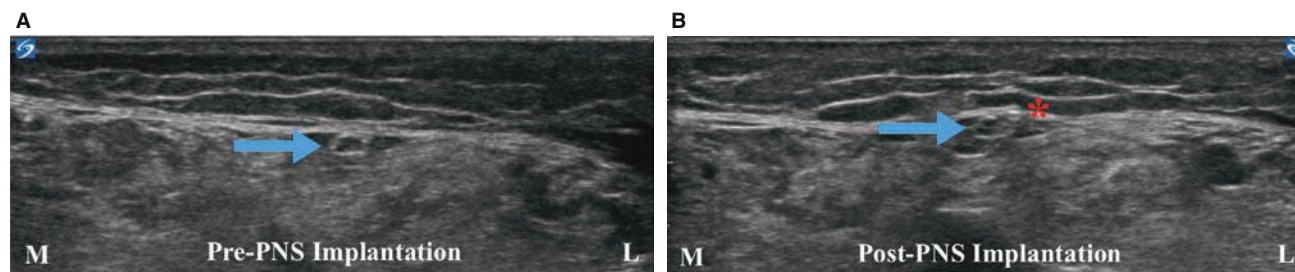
A, Intraoperative ultrasound imaging showcasing the trajectory of the superficial peroneal nerve between the anterior and lateral leg compartments (before stimulator implantation). Blue arrow points to the superficial peroneal nerve (fascicular bundle to the right of the arrow). L, lateral; M, medial; PNS, peripheral nerve stimulator. B, Intraoperative ultrasound imaging showcasing the percutaneous PNS placement along the trajectory of the superficial peroneal nerve between the anterior and lateral leg compartments (after stimulator implantation). *Peripheral nerve stimulator (bright white spot to the left of the asterisk). Blue arrow points to the superficial peroneal nerve (fascicular bundle to the right of the arrow).
